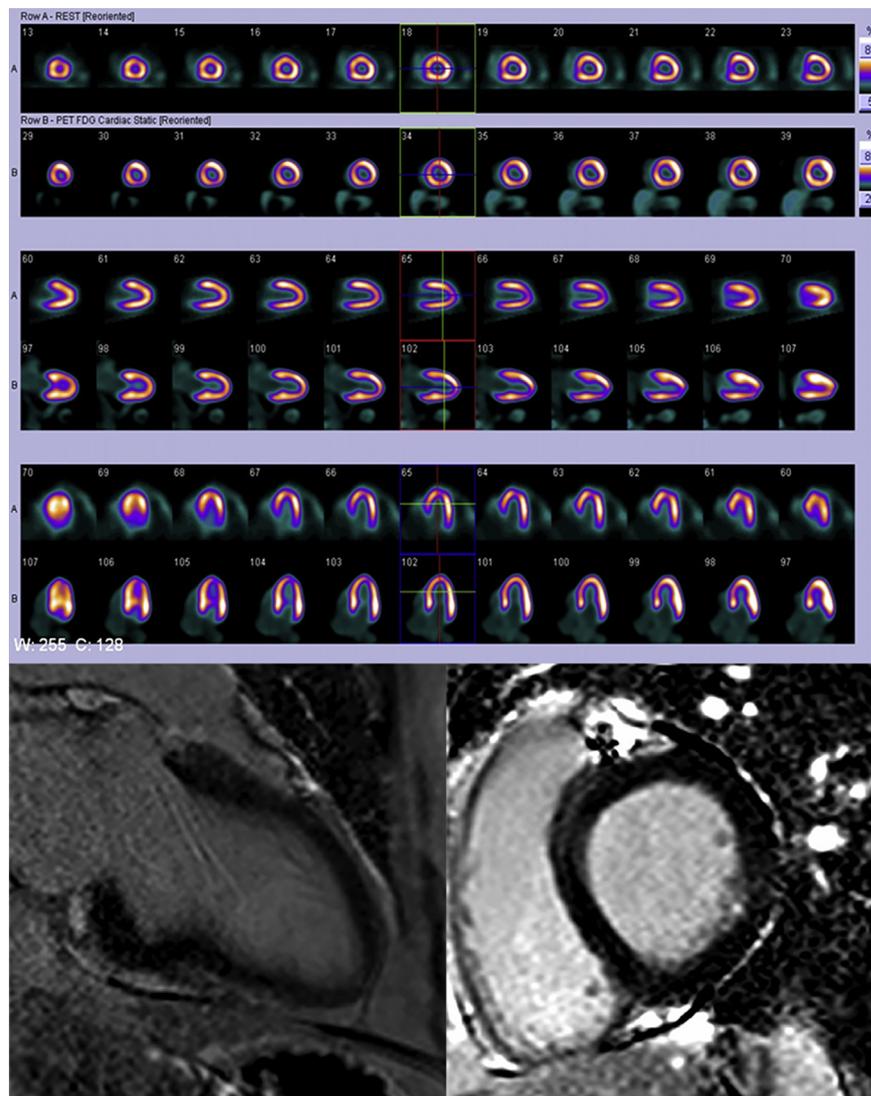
In a patient with chronic total occlusion of LCX, short axis, horizontal long axis, and vertical long axis SPECT perfusion (top row) and ^{18}F -FDG PET (bottom row) images were normal in all myocardial segments (normal) and short axis and vertical long axis cardiac MRI images showed that the LGE of corresponding myocardial segments was 0%.
